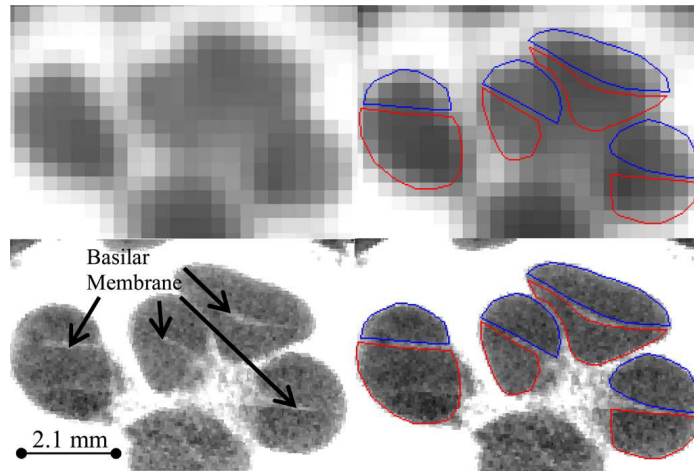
Example of cochlear segmentation (from [Noble 2011]). Segmentation of the scala tympani (red) and the scala vestibuli (blue) are shown on CT (top) and μ CT (bottom) images.
